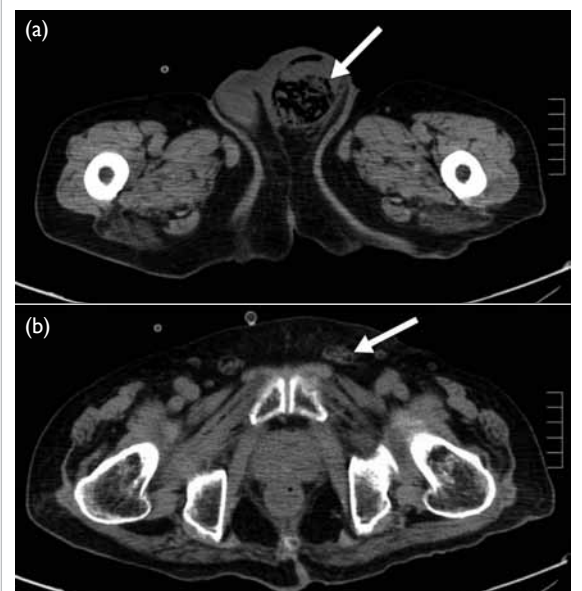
Axial computed tomography of the pelvis showing (a) mottled gas densities confined to the left hemiscrotum (white arrow) with no evidence of gas in the subcutaneous layer of the scrotum or perineum, virtually excluding the possibility of Fournier's gangrene; and (b) absence of bowel loop in the left inguinal canal (white arrow) excluded the possibility of incarcerated indirect inguinal hernia
